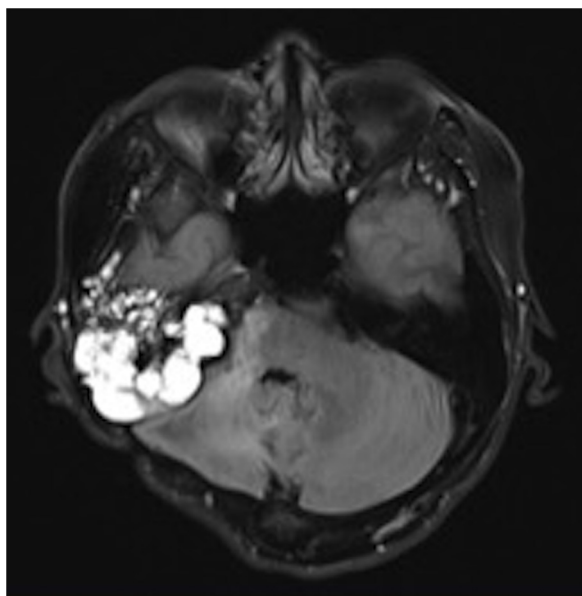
Axial view of the MRI (T1-weighted with Gadolinium contrast) showing multi-lobulated cystic lesions occupying the right mastoid air cells, middle ear, inner ear, internal auditory canal and petrous apex.
